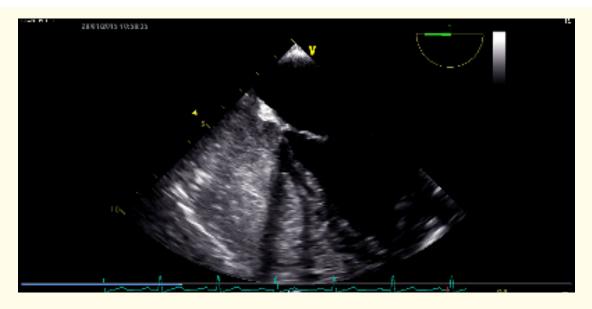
Baseline chest x-ray (A) shows a well-defined nodular opacity in the right lower lung zone. Reformatted coronal MIP* image from CT pulmonary angiogram (B) shows multiple filling defects in the right lower lobe pulmonary artery and an AVM in the right lower lung lobe (arrow). Trans-esophageal contrast echocardiography shows no intracardiac shunt in initial cardiac cycles (C) and appearance of air bubbles in left heart chambers after 4th and 5th cardiac cycles (D), suggestive of extra-cardiac intrapulmonary right-to-left shunt. *MIP: Maximum intensity projection.
